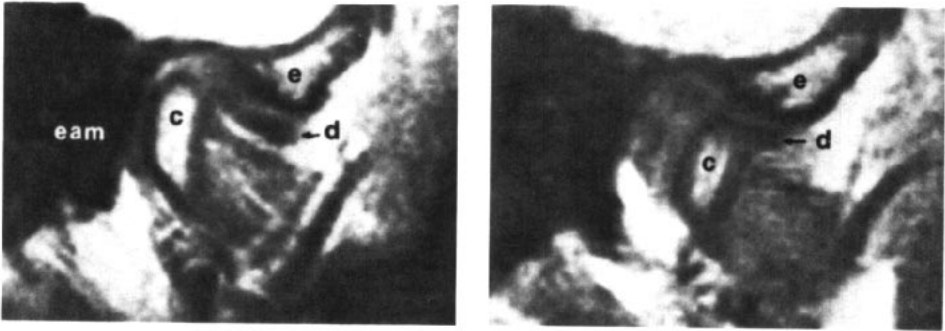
MRI of anterior disc displacement with reduction.
